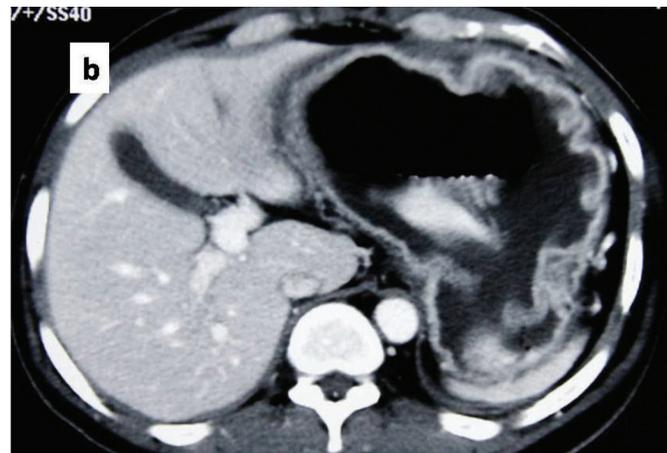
Symmetric mucosal enhancement on CT scan
